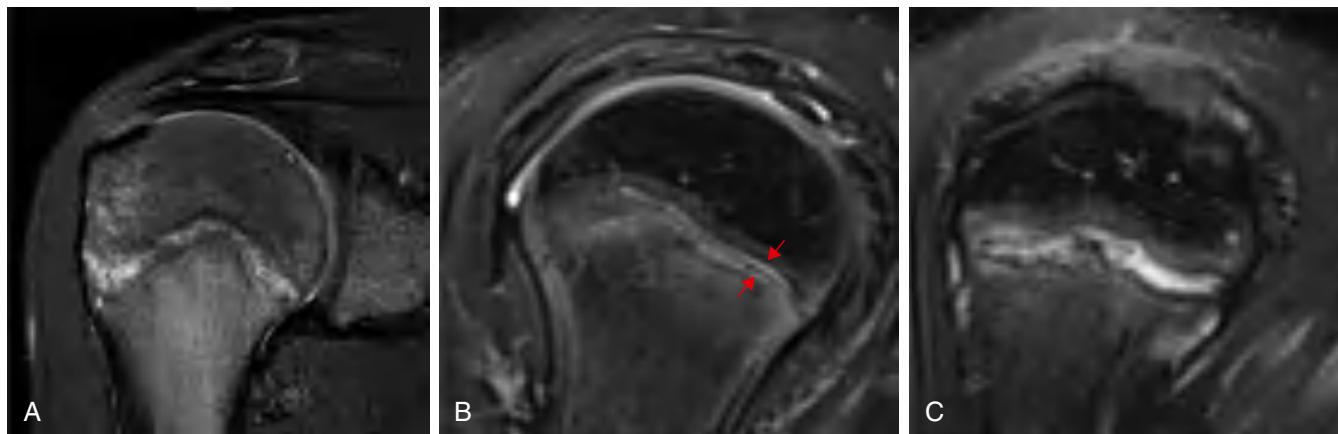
Little League shoulder MRI findings. A, Coronal oblique fat-saturated T2 weighted image in a 12-yr-old pitcher demonstrates diffuse proximal humeral primary physseal widening and undulation with bone marrow edema within the metaphysis and lateral epiphysis. B and C Sagittal oblique fat-saturated T2 weighted images obtained in a 13-yr-old pitcher demonstrate preservation of the normal anterior medial humeral physis (arrows) in contrast to the widened irregular physis posteriorly and laterally. (From Braithwaite KA, Marshall KW. The skeletally immature and newly mature throwing athlete. Radiol Clin N Am. 2016;54:841–855.)
